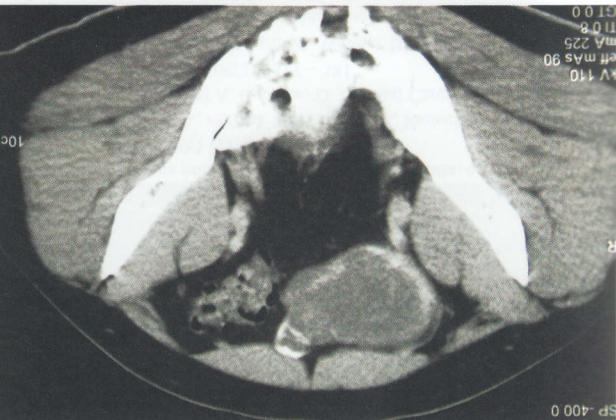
CT-Scan showing the right-sided intra-abdominal cystic mass with peripheral calcifications
